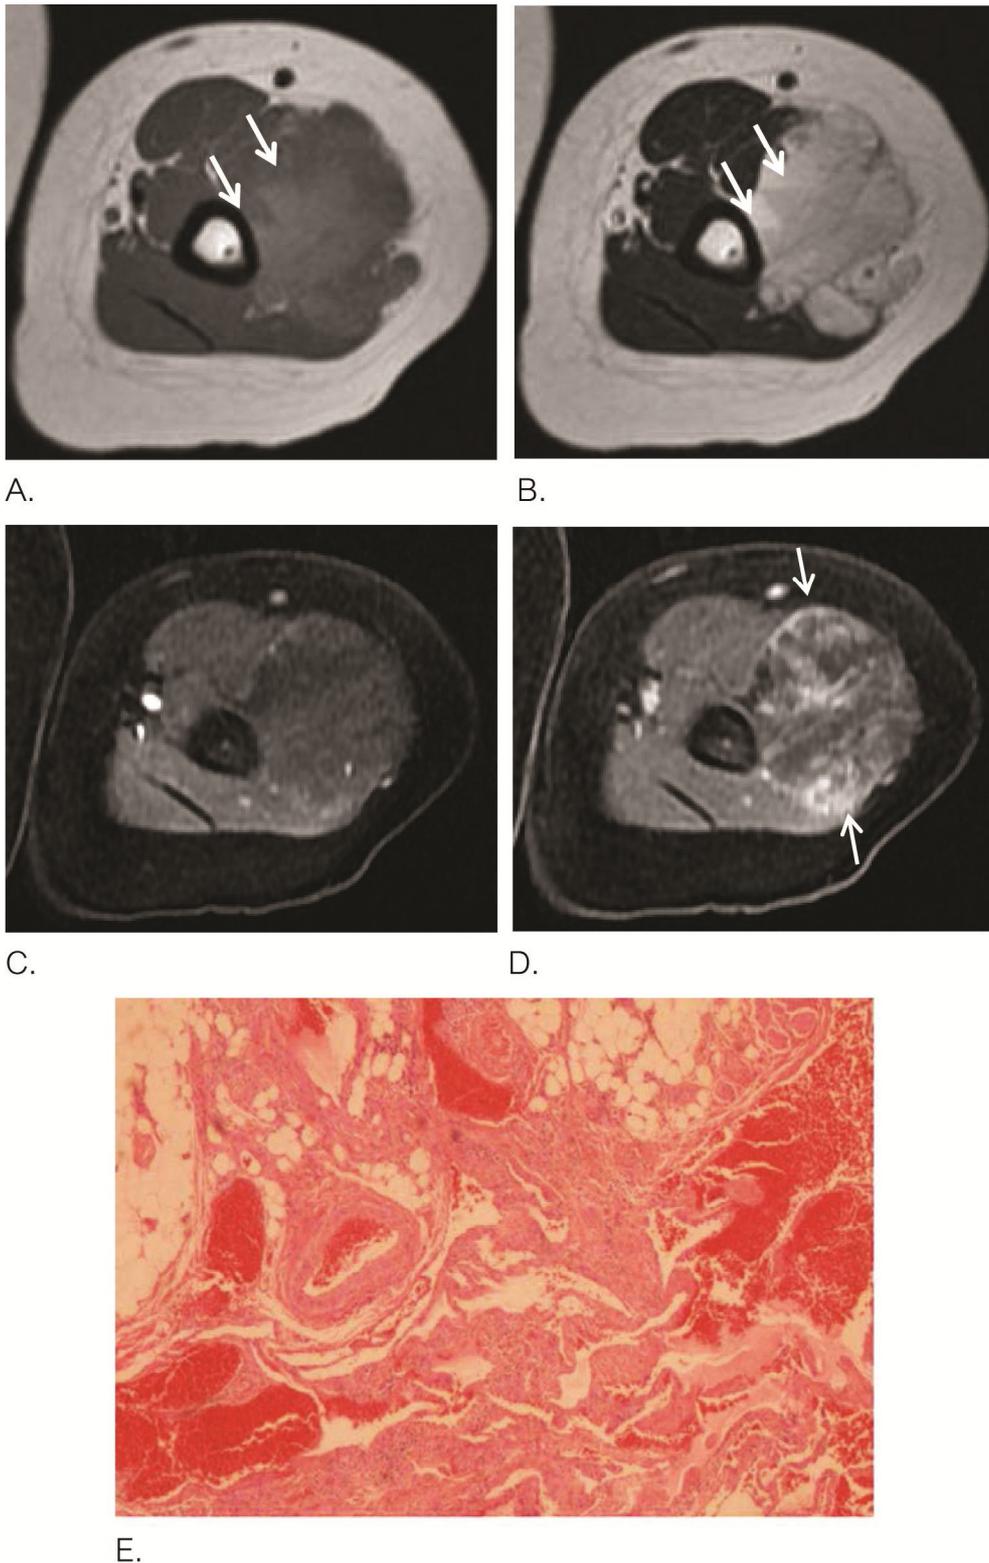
MR imaging of the left arm of a 7-year-old boy. Axial T1-weighted A.) and axial T2-weighted images B.) reveal intramuscular multilobulated mass with internal fluid-fluid level (arrows). Axial images from multi-phase dynamic contrast-enhanced study show no enhancement of the lesion in arterial phase C.) and heterogeneous enhancement (thin arrows) on delayed phase D.). E.) The pathological diagnosis is AVM.
